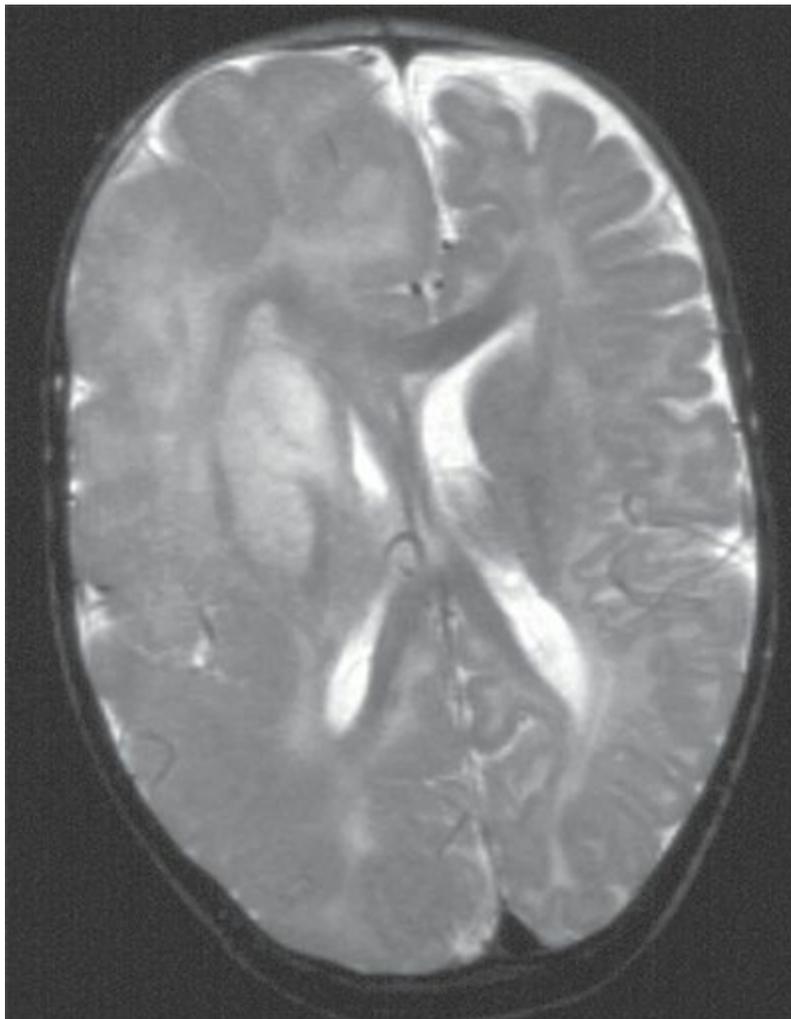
T2-weighted sagittal image of “typical” hemimegalencephaly showing diffuse right hemispheric enlargement and dysplasia. Midline shift with bulging of anterior falx to the left and compression of the right lateral ventricle suggests a mass effect as a result of increased volume of the brain parenchyma. Dysplastic changes are diffuse, with thick and disorganized cortex, poor gray–white matter differentiation, and abnormal signal in the white matter. Note that the basal ganglia are also dysplastic with abnormal increased signal.
